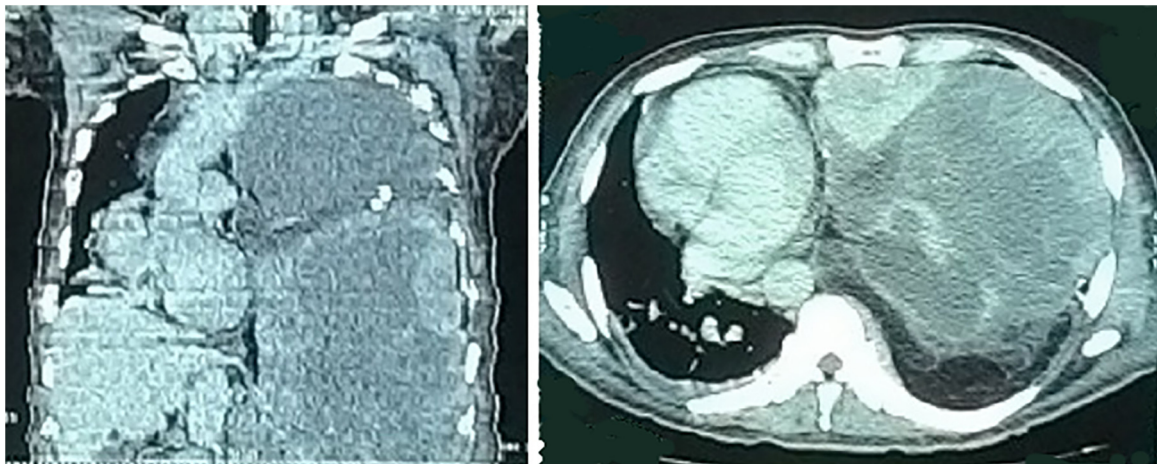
The coronal and axial view of chest CT Scan revealed an inhomogeneous fatty mass in the left hemithorax, shifting heart and trachea to the right.
